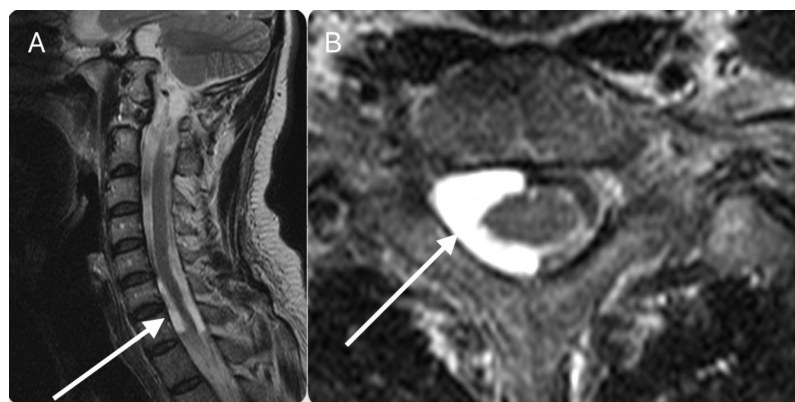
T2-Sagittal MRI shows compartmentalization of the subarachnoid space in the cervical cord, identifying a cystic, extramedullary, right lateral intradural lesion that surrounds the cord without mass effect at the level of T7.
